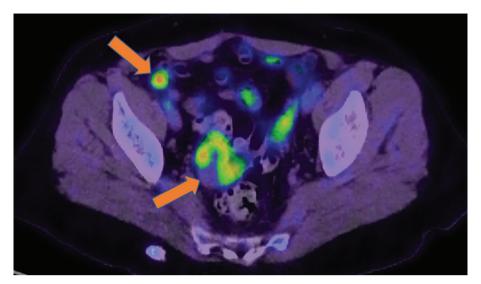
Restaging. ¹⁸F-FDG PET/CT images obtained from a 69-yr-old patient with Stage IIIC ovarian carcinoma, post debulking surgery and completion of 3rd line chemotherapy, referred for restaging (in the absence of baseline imaging). Arrows indicate the metabolically active primary ovarian tumor in the right adnexa and a right-sided metastatic iliac lymph node.
